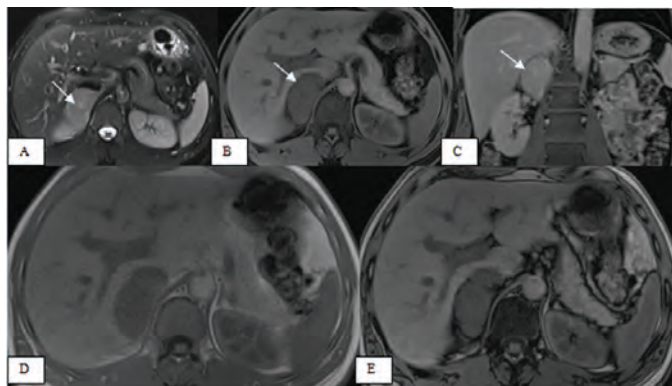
Magnetic resonance imaging showing the mass on T2w image having high signal intensity relative to the liver but not as much as expected from a pheochromocytoma (A, arrow). Precontrast T1w (B, arrow) and postcontrast T1w (C) images show homogenous enhancement of the lesion (C, arrow). There was no drop in signal intensity out of phase imaging (A; in phase and B; out of phase)
